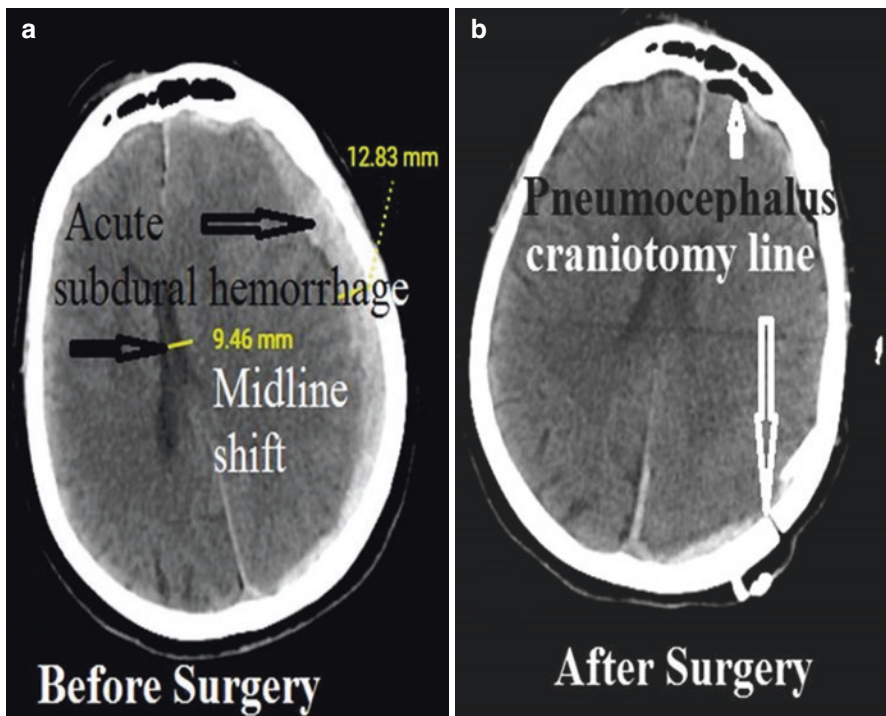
(a) Shows the computed tomography images of a patient with acute subdural hematoma. His hematoma thickness is 12.88 mm, and the patient also has a 9.46 mm midline shift. (b) Shows the resolution of the midline shift after surgery
